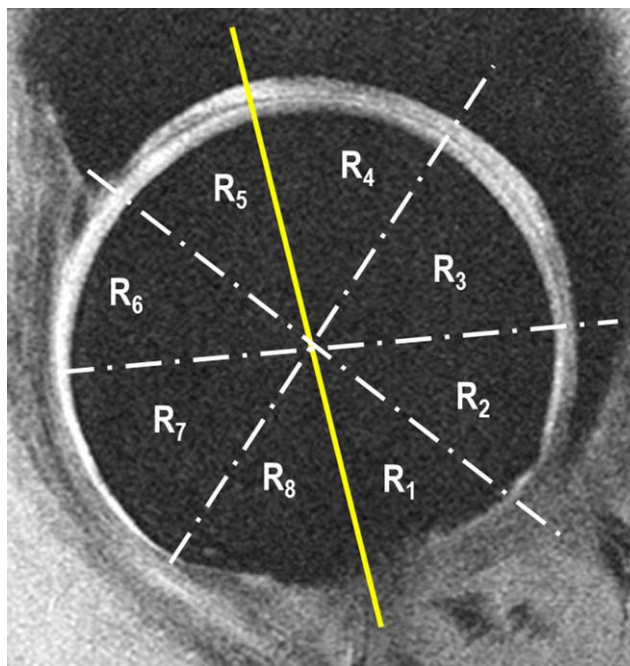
Division and numbering of the 8 subregions (R1–R8) of the hip cartilage on a representative magnetic resonance image acquired using multiecho spoiled gradient-recalled acquisition in the steady state. The solid yellow line represents a line parallel with the femoral neck that is drawn for each subject.
